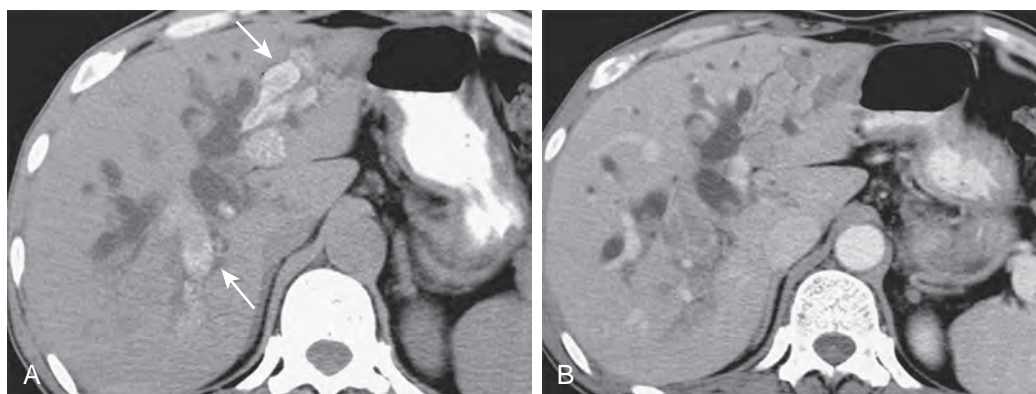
Recurrent pyogenic cholangitis: utility of noncontrast CT. A. Precontrast CT scan shows cast of stones in dilated intrahepatic ducts (arrows). B. After intravenous administration of contrast material, stones are less conspicuous.
